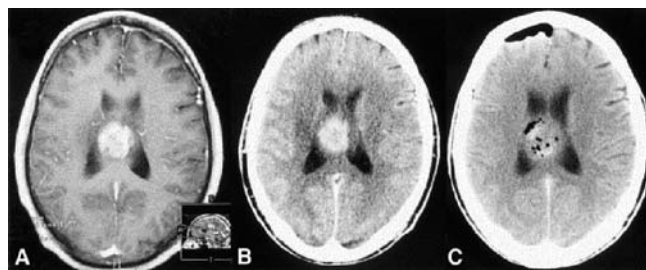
Administration of anticancer drug-loaded, biodegradable microparticles into human, *inoperable* brain tumors: A pre-operative magnetic resonance image showing a malignant glioma, B pre-operative computed tomography (CT) scan, C CT scan after implantation of the microspheres (reprinted from [15], with permission)
